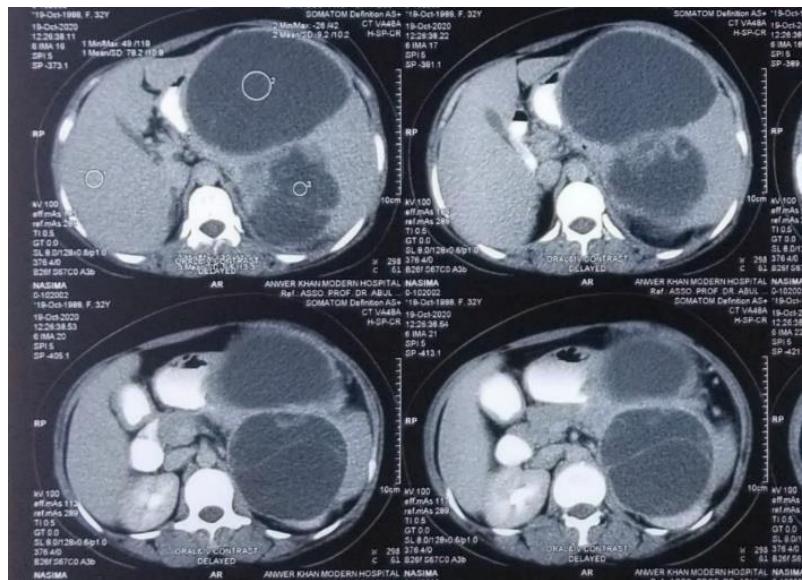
CT scan of Hydatid cyst
